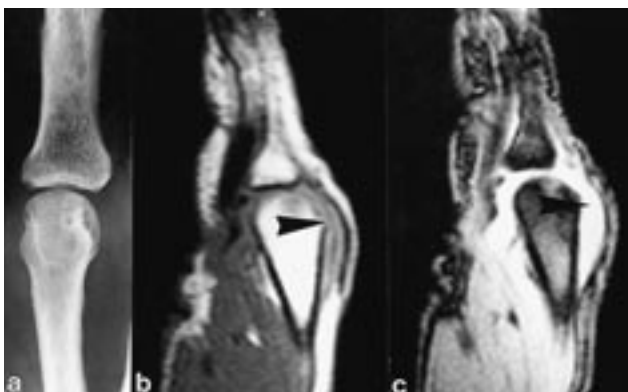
(a) The radiography of the III metacarpo-phalangeal shows a joint effusion; however, it is not clear if there is also periarticular involvement. (b), (c) The MR images show mild distension (arrows) of the III metacarpo-phalangeal joint without subcutaneous and tendon involvement.
